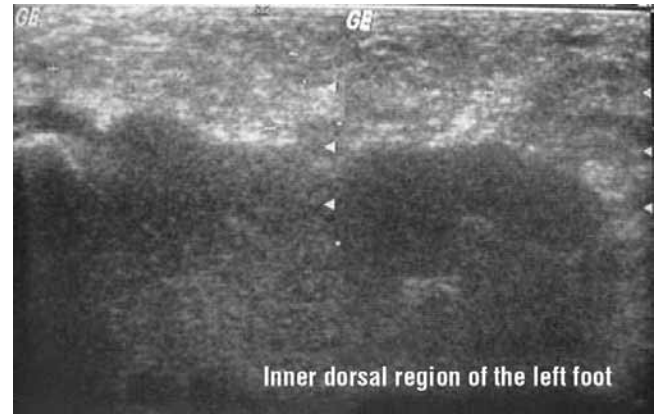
Ultrasound of the soft tissue of the medial plantar region of the left foot. Hypoechoic, homogeneous, oval tumor with regular and well-defined edges.
